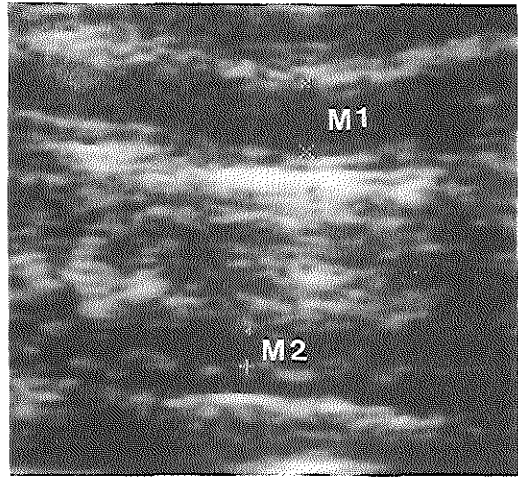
B. Longitudinal sonogram of Roux-Y loop demonstrating reduction of mucosal layer (corresponding to Figure 1, Chapter 5, R-Y 3).
